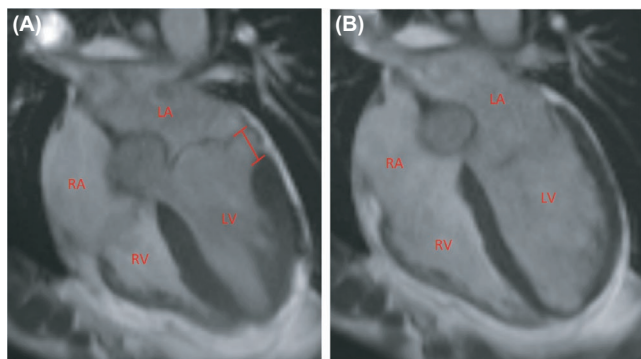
Cardiac magnetic resonance image showing mitral annular disjunction in ventricular systole (A) which is not present in diastole (B)
